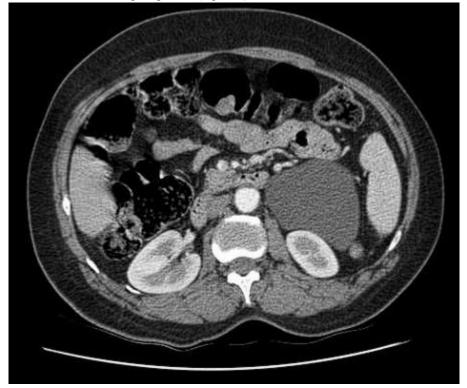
Axial abdominal CT scan showing a cystic mass in the spleno-renal space.
